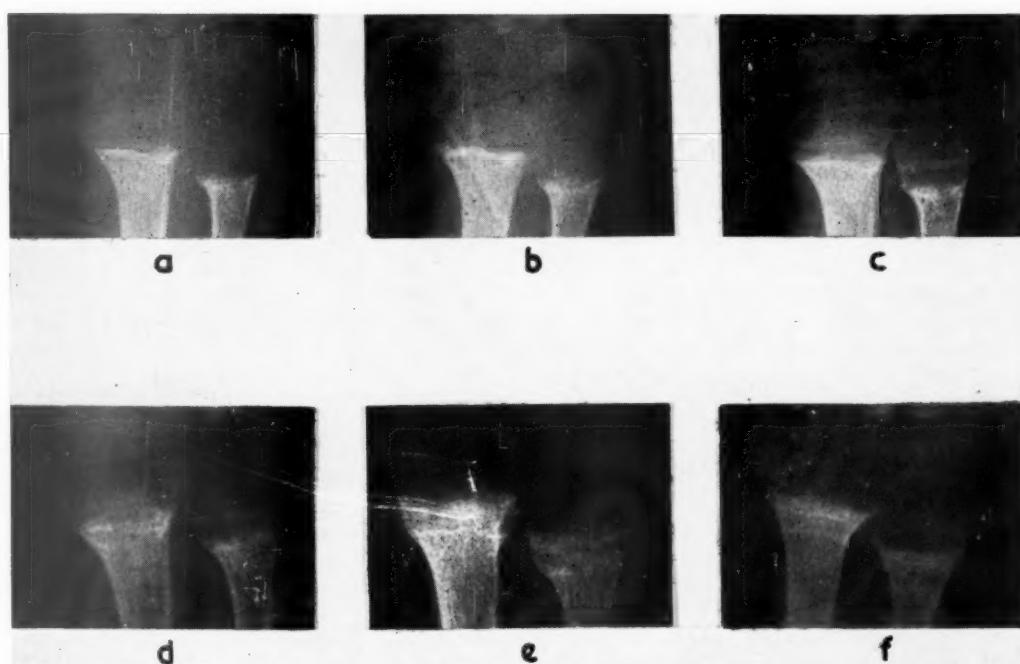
Radiographs of the right wrist.
